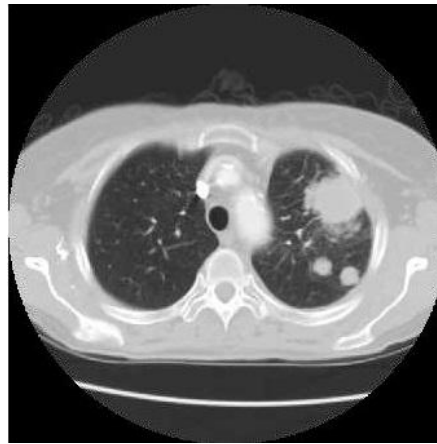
Example of Lung Cancer CT Scan
